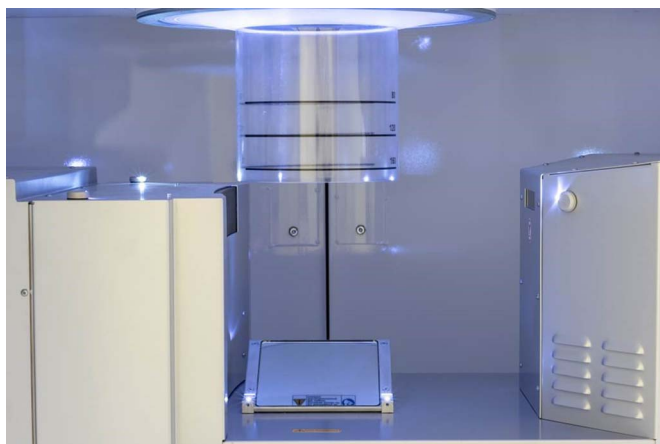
The examination table has a horizontal CT gantry, and the examined breast is placed in a table aperture in a plastic cylinder without compression. The maximum possible breast volume to examine has a diameter of 190 mm and a height of 160 mm. Scan length can be adjusted at 3 different levels (80, 120, and 160 mm) depending on the anteroposterior breast diameter.
